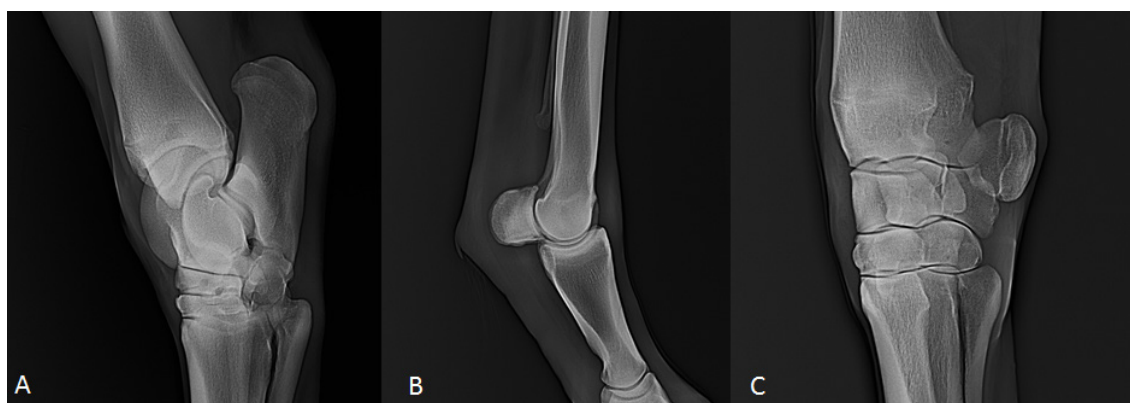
Post-treatment radiographic images of the cases given in Figure 1.
